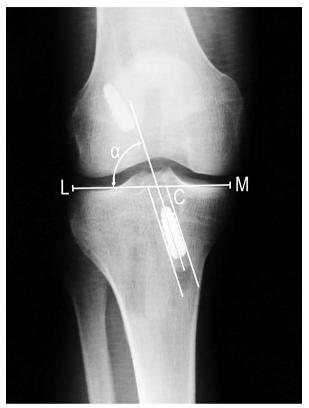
Anteroposterior X-ray measurements Slika 1. Merenja na anteroposteriornom rendgenskom snimku
